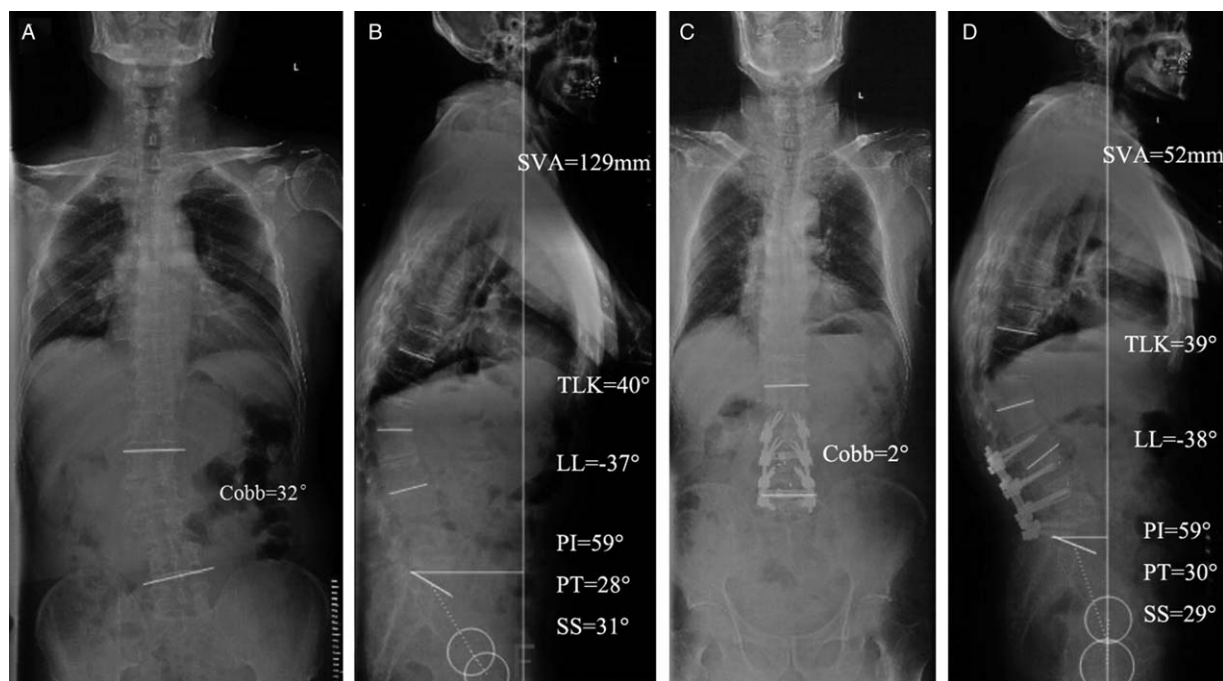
A 75-year-old female with Lenke-Silva level VI degenerative scoliosis was treated with short-segment decompression/fusion. Pre-operative anteroposterior (A) and lateral (B) X-ray indicated lumbar Cobb angle = 32°, SVA = 129 mm, LL = -37°, PT = 28°, PI = 59°, SS = 31°, and TLK = 40°. Post-operative anteroposterior (C) and lateral (D) X-ray at the last follow-up of 1.5 years showed the fusion segments of L2-L5 and no osteotomy, lumbar Cobb angle = 2°, SVA = 52 mm, LL = -38°, PT = 30°, and SS = 29°. SVA: Sagittal vertical axis; LL: Lumbar lordosis; PT: Pelvic tilt; SS: Sacral slope; PI: Pelvic incidence; TLK: Thoracolumbar kyphosis.
